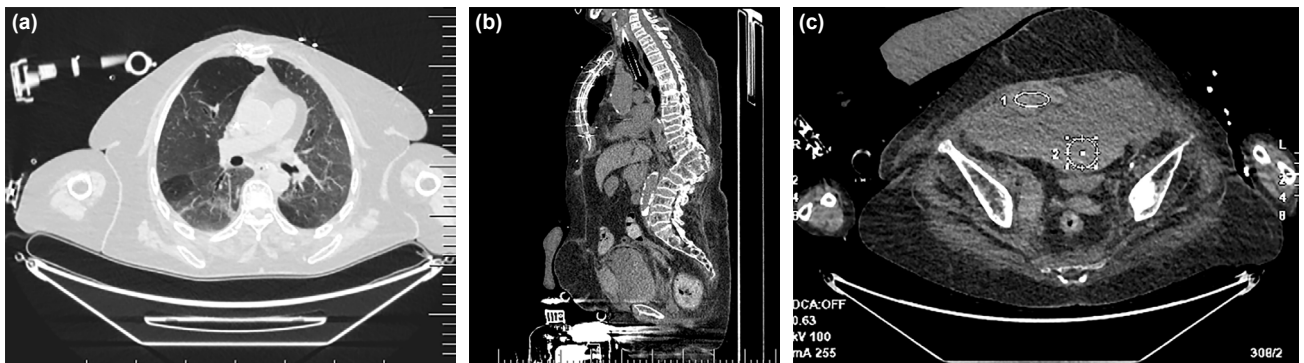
Case 1 – (a) Thorax CT and viral pneumonia compatible with COVID-19, (b) abdominopelvic computed tomography (CT), sagittal image, right rectus sheath hematomas (RSH), and (c) abdominopelvic CT, axial image, right RSH ruptured into the abdominopelvic cavity.
